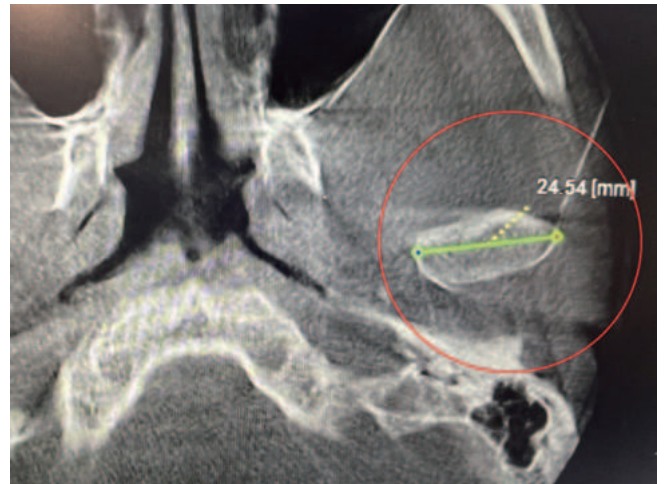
The mandibular condyle should be located at the intersection of the ultrasound probe's scanning path and the needle's insertion trajectory.
